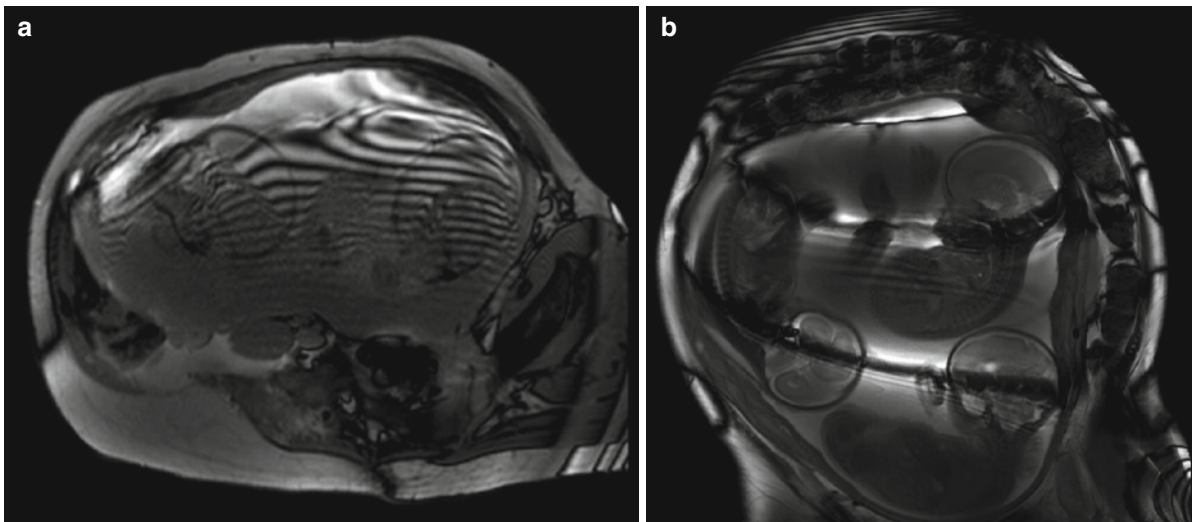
Bending artifact in fetal MRI at higher field strength. Axial (a) and coronal (b) image of band-shaped signal losses (banding artifact) in steady-state free precession (SSFP)
